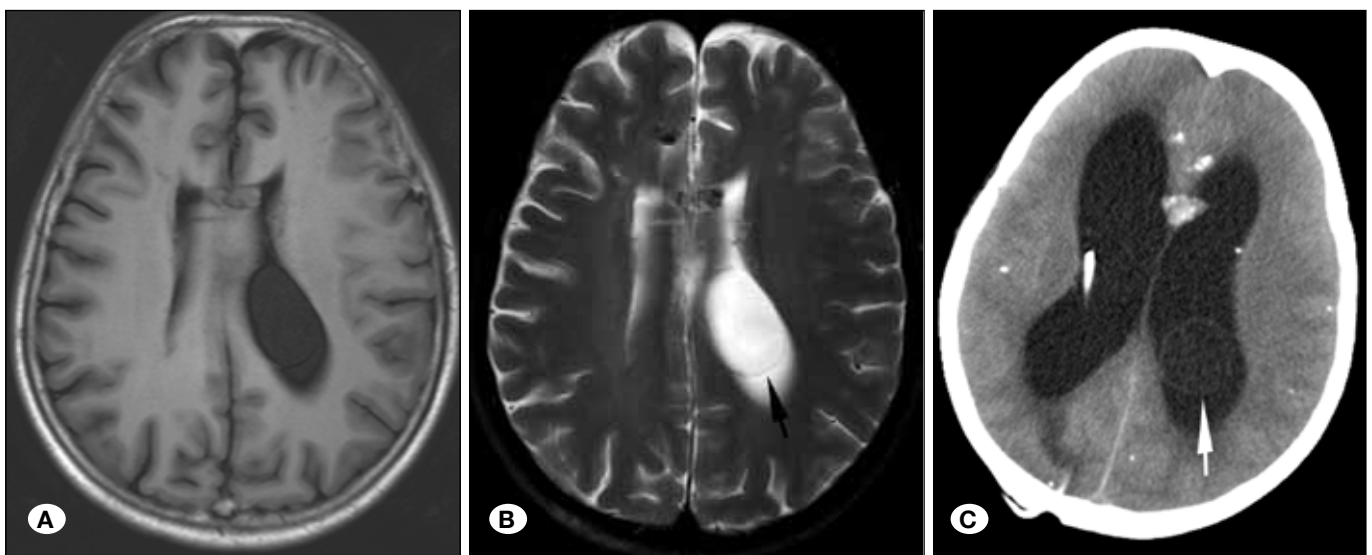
A 40-year-old female with intraventricular NCC. A) T1WI, B) T2WI, C) Postoperative brain CT at the 3rd month after VP shunt. A cystic lesion with long T1 and T2 signals was found in the dilated left ventricle with a thin capsule (B, Arrow). A simple VP shunt without lesion excision was performed as the initial management. 3 months later, the brain CT revealed the original cyst floating in the ventricle (C, Arrow) and aggravated hydrocephalus, suggesting the failure of the VP shunt.
